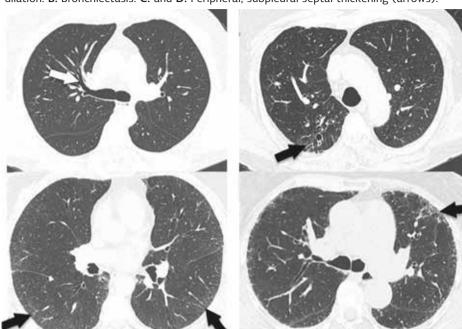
High-resolution computed tomography showing several abnormalities detected in elderly asymptomatic subjects. A: Central airway dilation. B: Bronchiectasis. C: and D: Peripheral, subpleural septal thickening (arrows).
